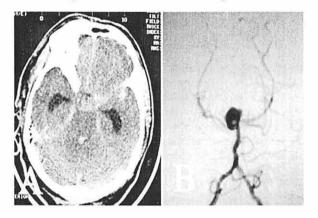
1A. Axial non-contrast-enhanced CT scanning on admission showed Fisher Grade 4 SAH in the basal cisterns and sylvian fissures, as well as acute hydrocephalus. 1B: Cerebral angiography (AP) of the vertebrobasilar system on day 2 of hospitalization revealed a saccular aneurysm of the basilar tip protruding cranially.
